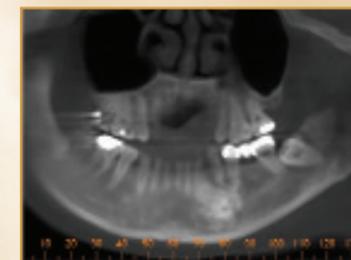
CBCT panoramic image (generated from CT data) of Case 2 patient showing location and extent of the lesion in the left mandible.
